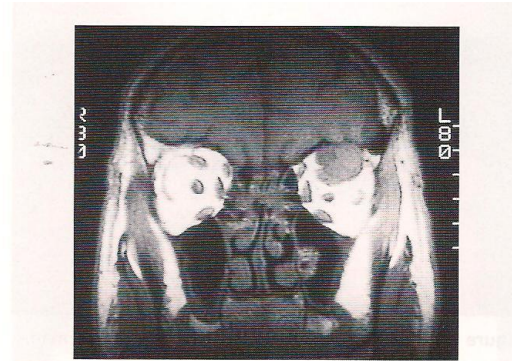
Coronal magnetic resonance imaging in T1-weighted image showing circumscribed superior orbital mass.
